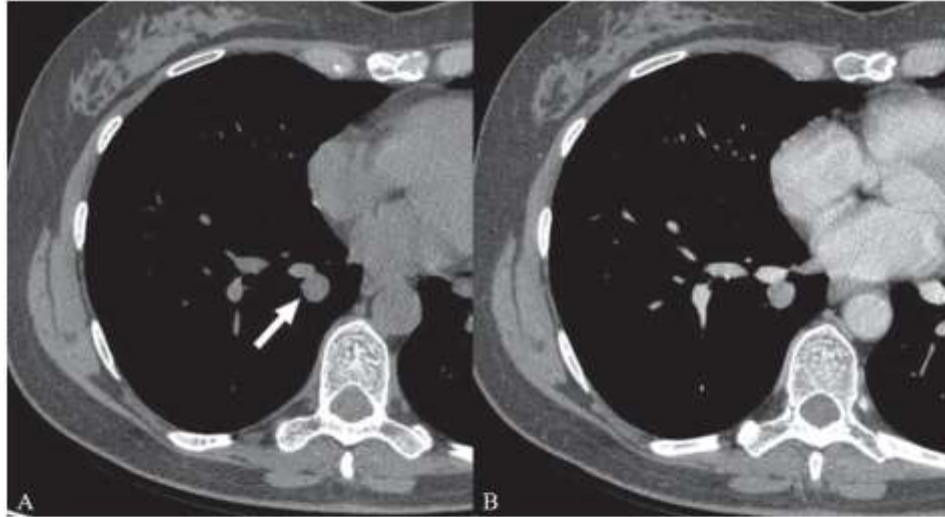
55-year-old woman with peripheral typical carcinoid tumor at lobectomy. CT contrast enhancement of right lower lobe nodule.
